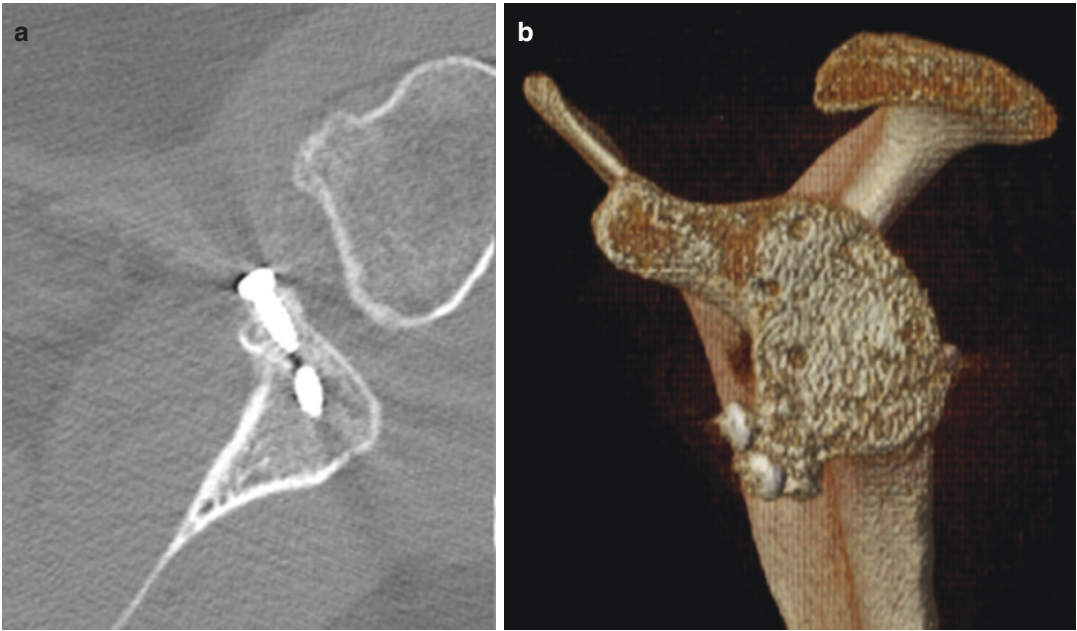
(a, b) Latarjet procedure. CT scans showing good placement and healing of the coracoid graft
